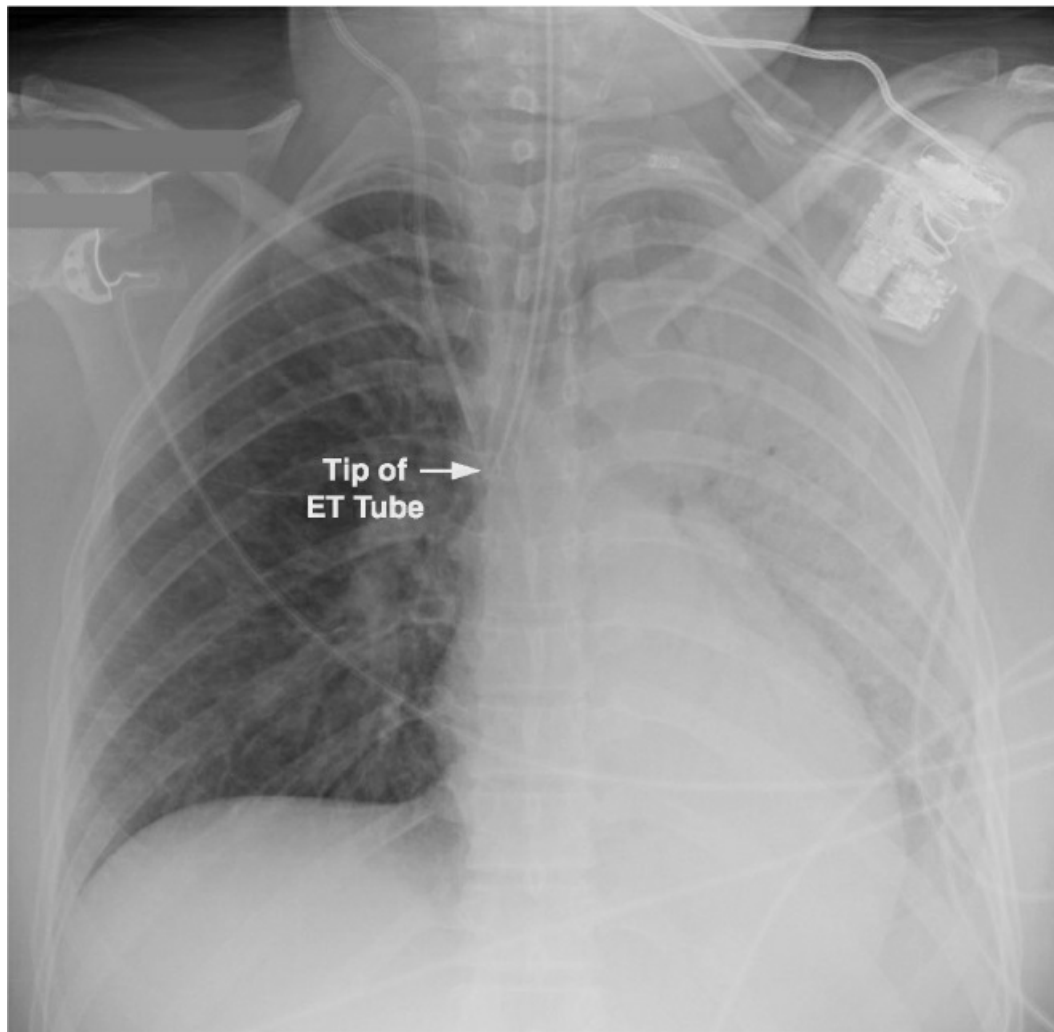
Portable chest x-ray showing intubation of the right mainstem bronchus and atelectasis of the non-ventilated left lung. Image from Reference 5.
